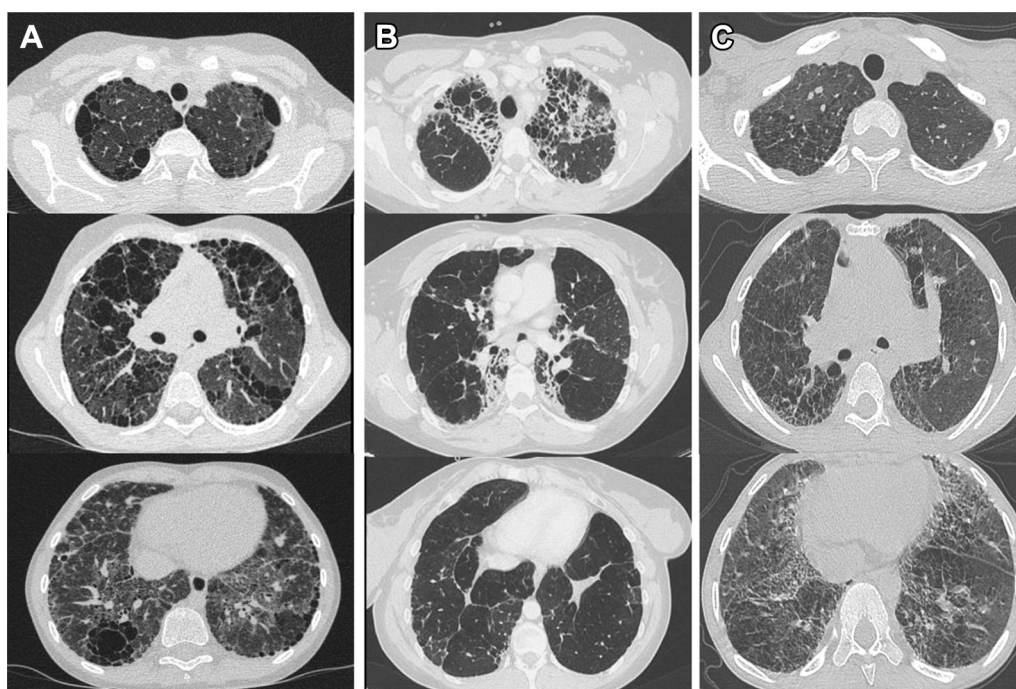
A, B, C, High resolution thoracic CT of the chest of familial (A and B) and sporadic (C) cases. Note the presence of cystic lesions (paraseptal emphysema) in upper lobes in the three cases. In case 1 (A), there is a clear subpleural distribution in the upper lobes, and a right-side predominance of the lesion in case 3 (C). Ground glass areas were mainly found in the lower lobes in case 1 (A) and case 3 (C).
